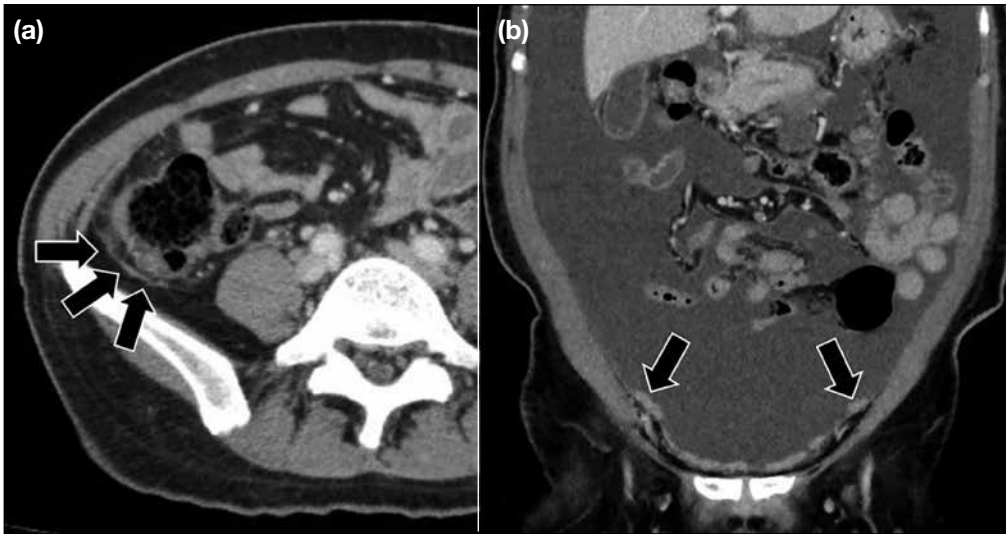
(a) Axial and (b) coronal images from contrast computed tomography demonstrating deposits at the paracolic gutters (arrows).
